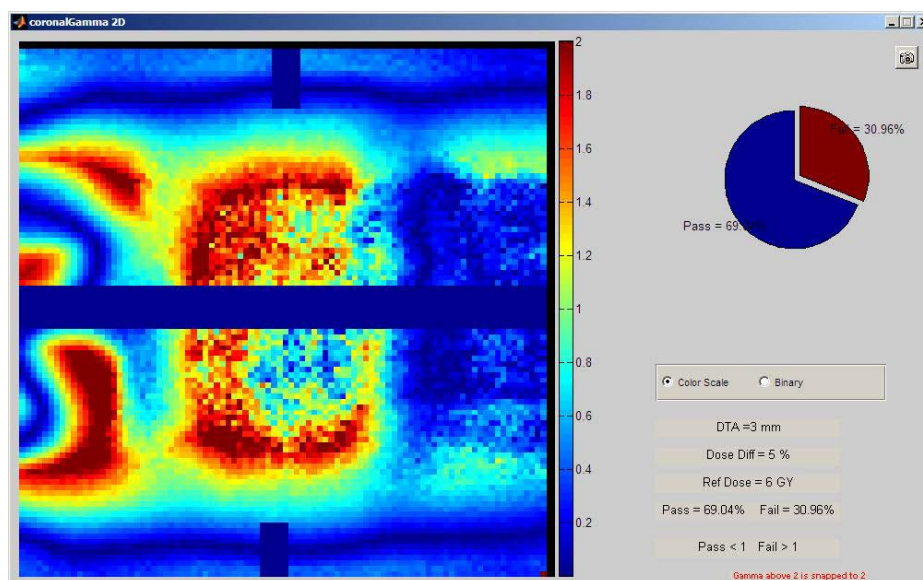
Plan 1a Trial 2 Coronal Gamma Analysis with PVC Shell contoured and CT Number set to match Eclipse Calibration Curve
